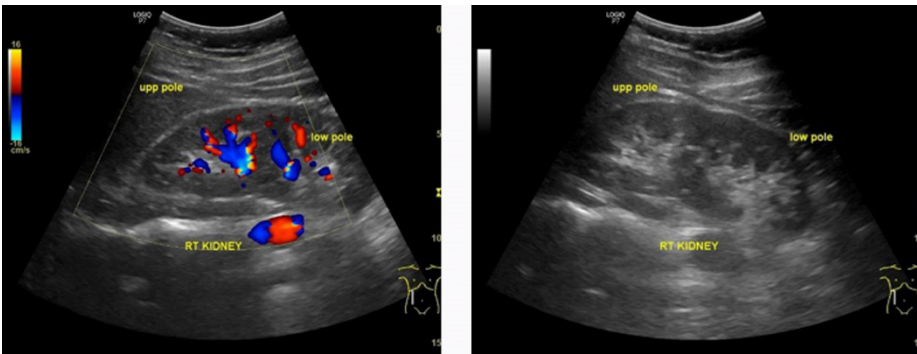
The right kidney ultrasonography revealed what appears to be a duplex collecting system; the two noncommunicating renal pelvices are seen as independent organs.
